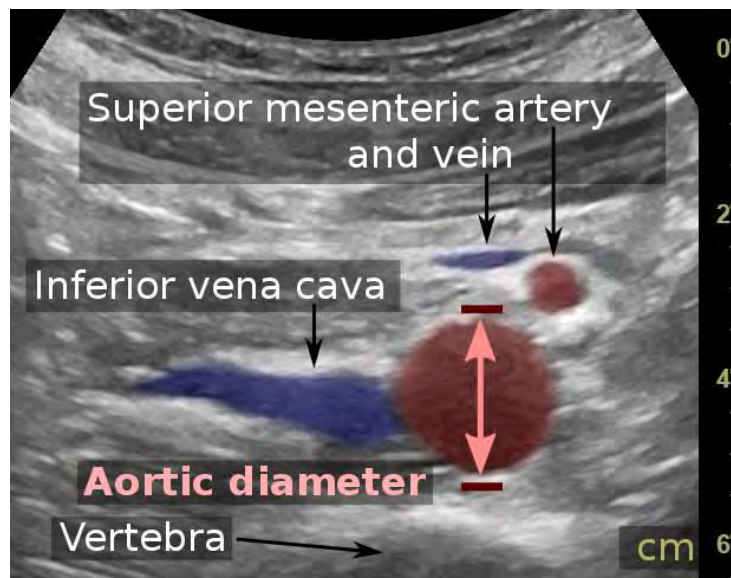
Measurement of abdominal aortic diameter by ultrasonography. Source: https://en.wikipedia.org/wiki/Abdominal_aortic_aneurysm#/media/File:Ultrasonographic_measurement_of_aortic_diameter_at_the_navel.svg
